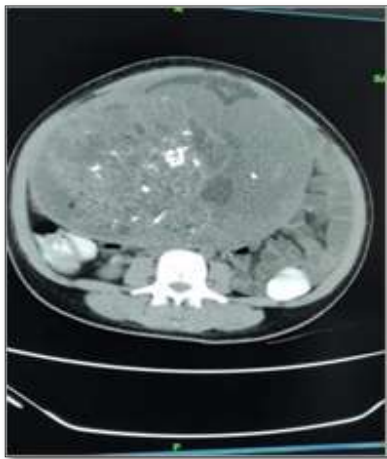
CT showing pelvic mass.
